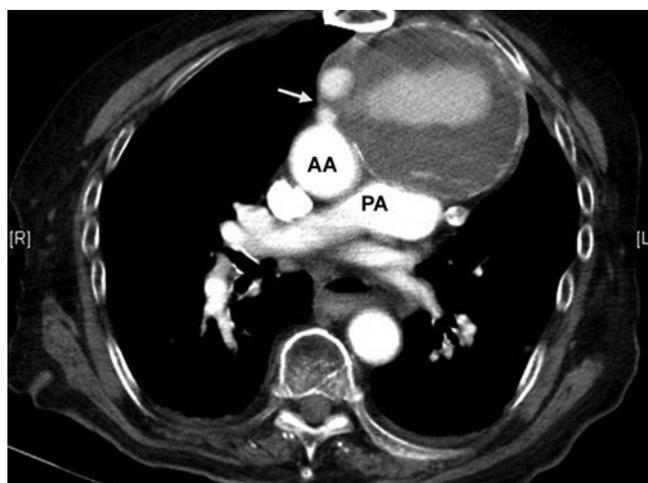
Computed tomography (CT) of the chest showing the pseudoaneurysm originating from the diagonal coronary artery bypass graft (arrow). (AA: Ascending aorta; PA: Pulmonary artery).
